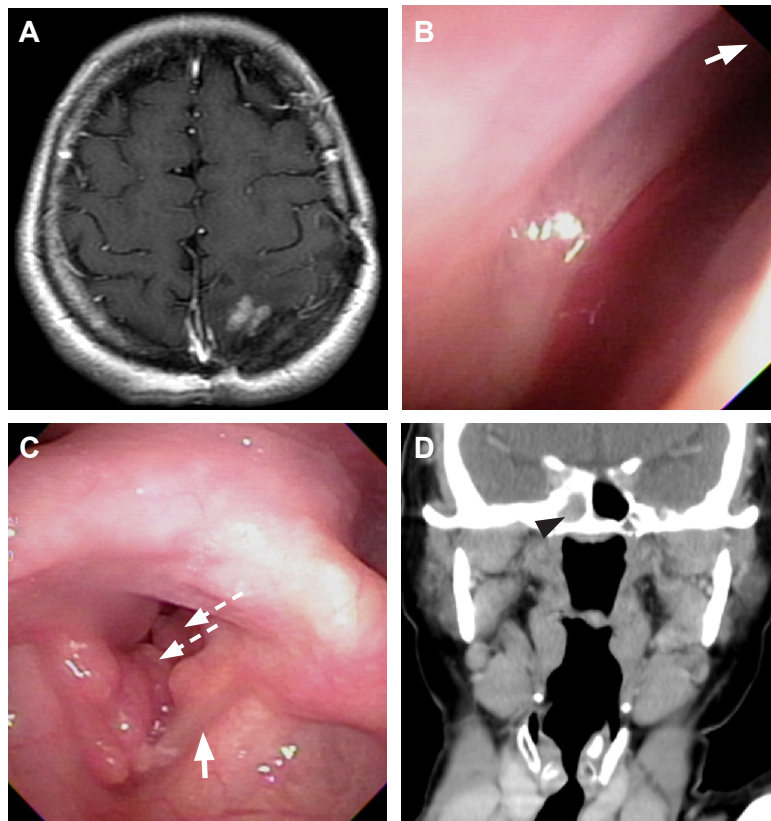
T1-weighted magnetic resonance imaging of the brain displaying an enhancing lesion over the left parietal region 10 months after tumor excision (A). Nasopharyngoscopic examination showing mild active bleeding from the orifice of the right sphenoid sinus (B, white arrow) and smooth polypoid mass lesions over the right glottic area and bilateral subglottic region (white dashed arrow) with impending airway compromise (C). Left vocal cord not involved (white arrow). Contrast-enhanced computed tomography showing the right sphenoid sinus radiopacity (D, black arrowhead).
